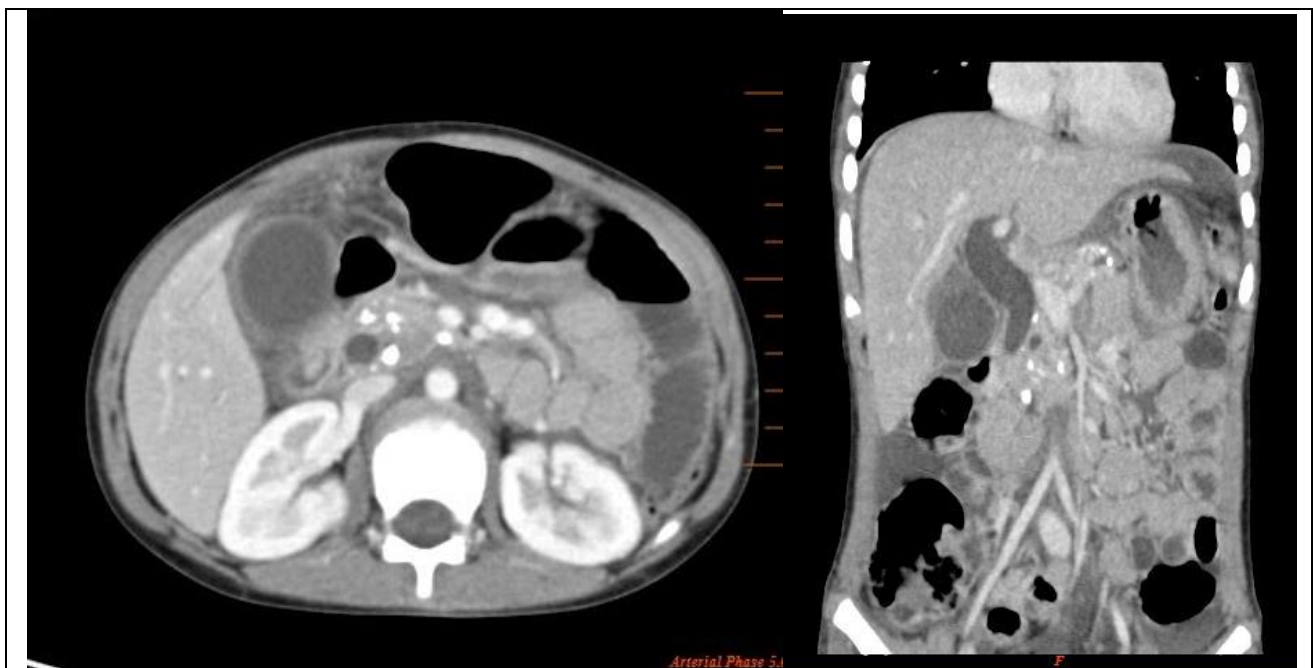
CT scan images of coronal and transverse view showing dilated common bile duct and perihilar collection of bile. Calcification in the pancreas can be noted in pancreatic parenchyma
